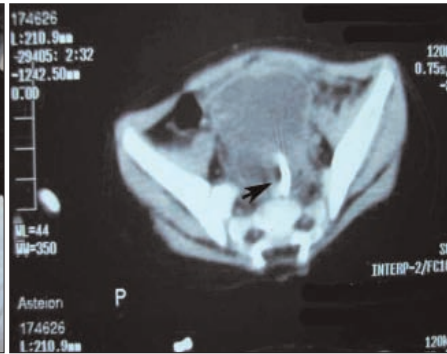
Abdominal computed tomography scan demonstrating a migration ventriculoperitoneal catheter in the lumen of the sigmoid colon (arrow).
